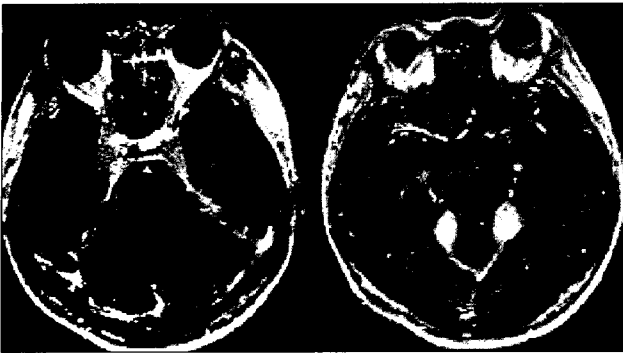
Initial enhanced T1-weighted magnetic resonance images showing the both cavernous sinus, both tentorial and anterior falx tumors.
